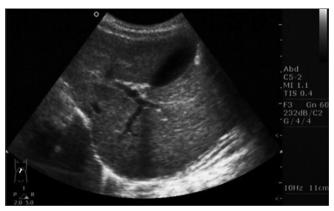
Followed up sonogram 15 days later showed dissolution of gallstone
